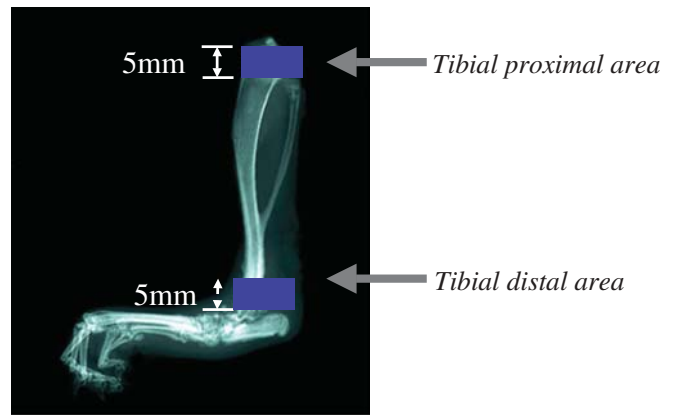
Dual-energy X-ray absorptiometry measurements of bone mineral density of tibial bones on the side opposite the adjuvant injection (DSC-600; Aloka)
